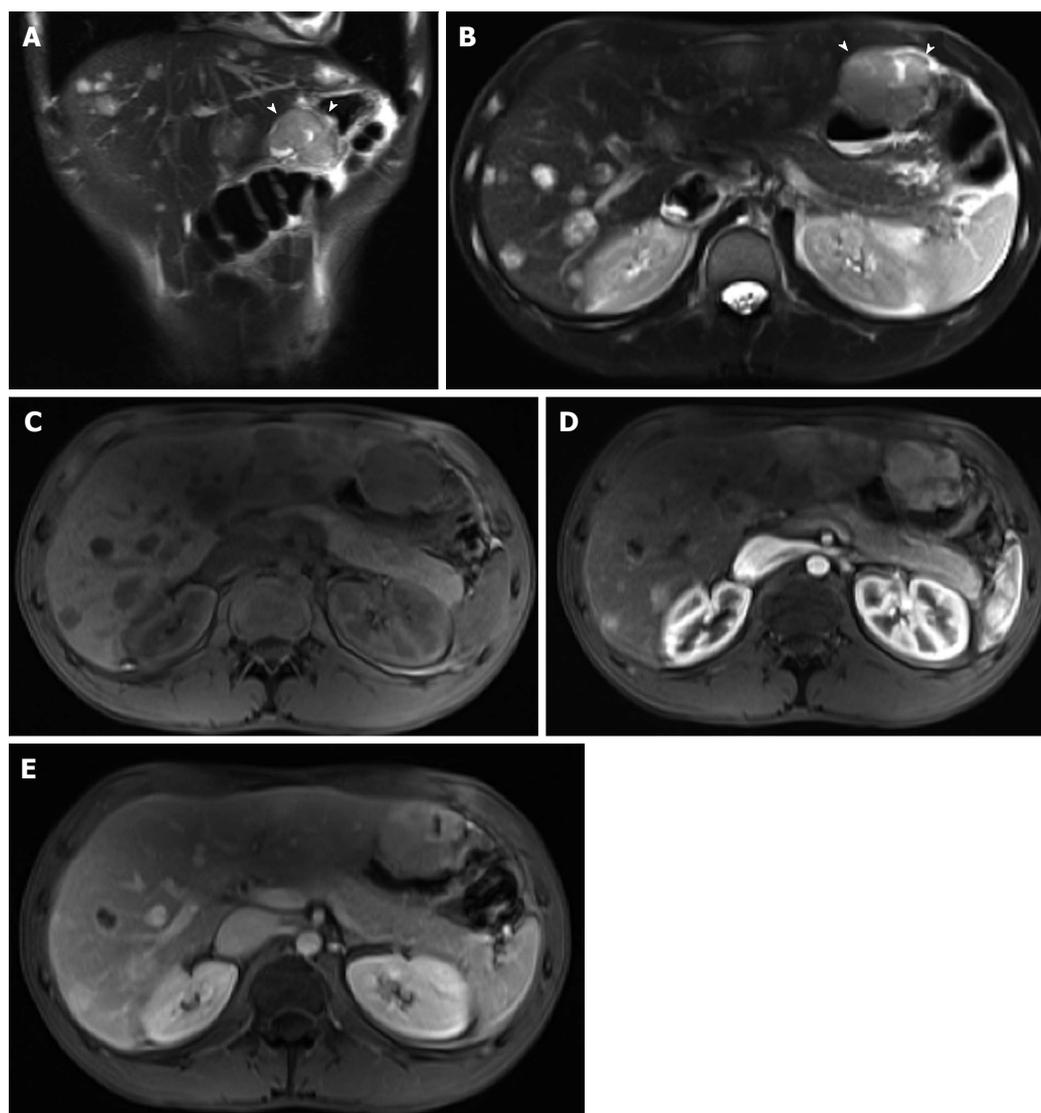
Metastatic malignant gastric gastrointestinal stromal tumors. A: Coronal T2-weighted single shot fast spin echo (SSFSE); B: Axial fat suppressed T2-weighted SSFSE; C: Pre- and post-gadolinium 3D-GRE T1-weighted images during the (D) arterial and (E) interstitial phases. There is a hyperintense mass within the wall of the gastric antrum, which abuts the edge of the left lobe of the liver; Central necrosis is seen (arrowheads, A and B). Multiple liver lesions show heterogeneously increased T2 signal and hypervascular characteristics, fading to isointensity on late phase of enhancement, consistent with metastases. GRE: Gradient recalled echo.
